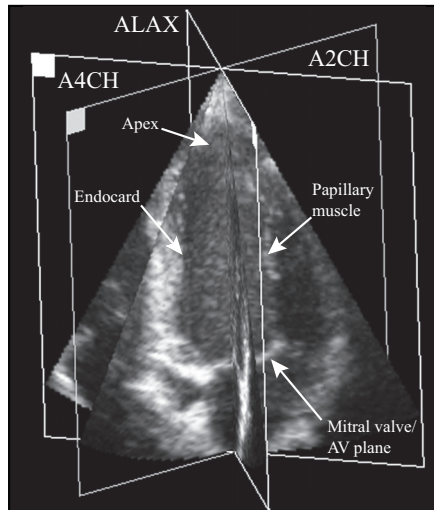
Triplane echocardiography allows simultaneous acquisition of three apical planes, including the standard apical four chamber (A4CH), two-chamber (A2CH), and the long axis (ALAX) views.
